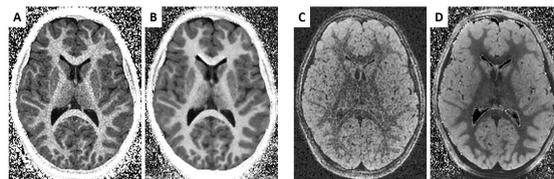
Representative synthetic FSPGR (A, B) and T2-FLAIR (C, D) images obtained from MRF maps of a pediatric patient, before (A, C) and after (B, D) CNN-based motion correction
